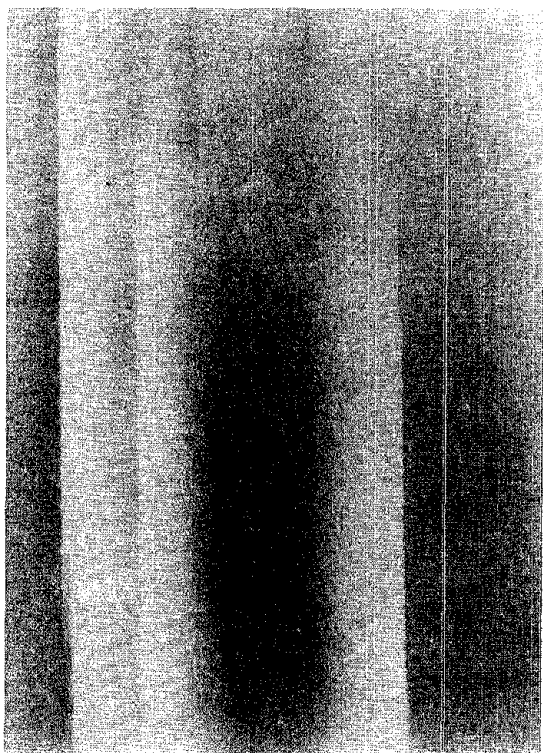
(left). Damage to an aluminum interspaced grid. Note the low-density (white) banding throughout the entire grid. This grid would be difficult to ignore on a chest radiograph. Unfortunately, if a grid damaged in this manner were used in a moving Bucky, this banding would be obliterated and the radiographic image would be of poor quality.
